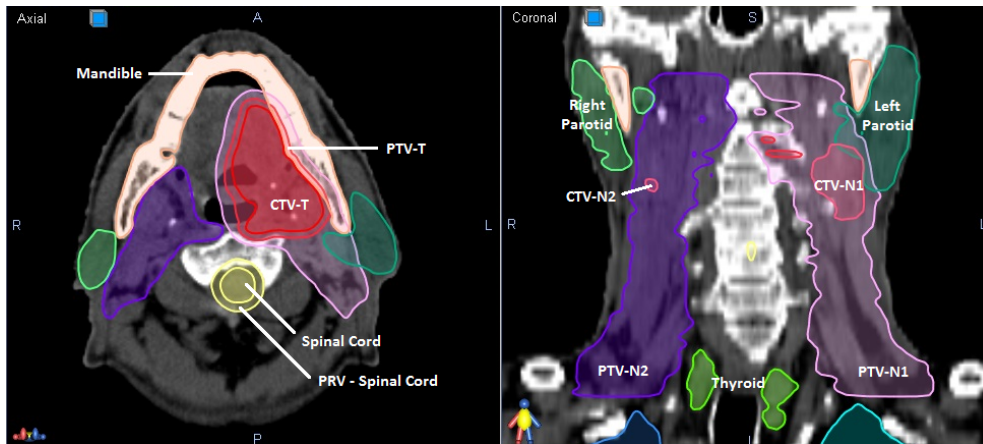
Two slices of a CT scan (axial on the left and coronal on the right) from a patient treated at IPOCFG. In this patient the organs at risk delineated were: mandible, spinal cord and margin – PRV-spinal cord –, thyroid, parotid glands and the target volumes to be treated (PTV-T: primary tumour; CTV-N1 and N2: adenopathies; PTV-N1 and N2: regions with a small probability of disease) [courtesy of IPOCFG].
